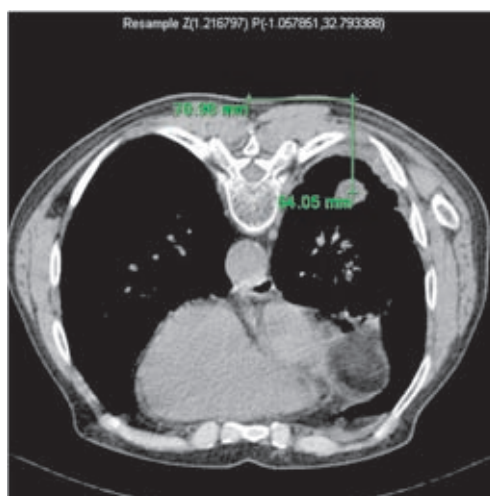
CT scan showing the puncture plan to diagnose the solitary pulmonary nodule in right lower lobe of 68-year-old man. Note the distance between the metal mark along the thoracic spine and the entry site and between the entry site and the centre of the nodule.
